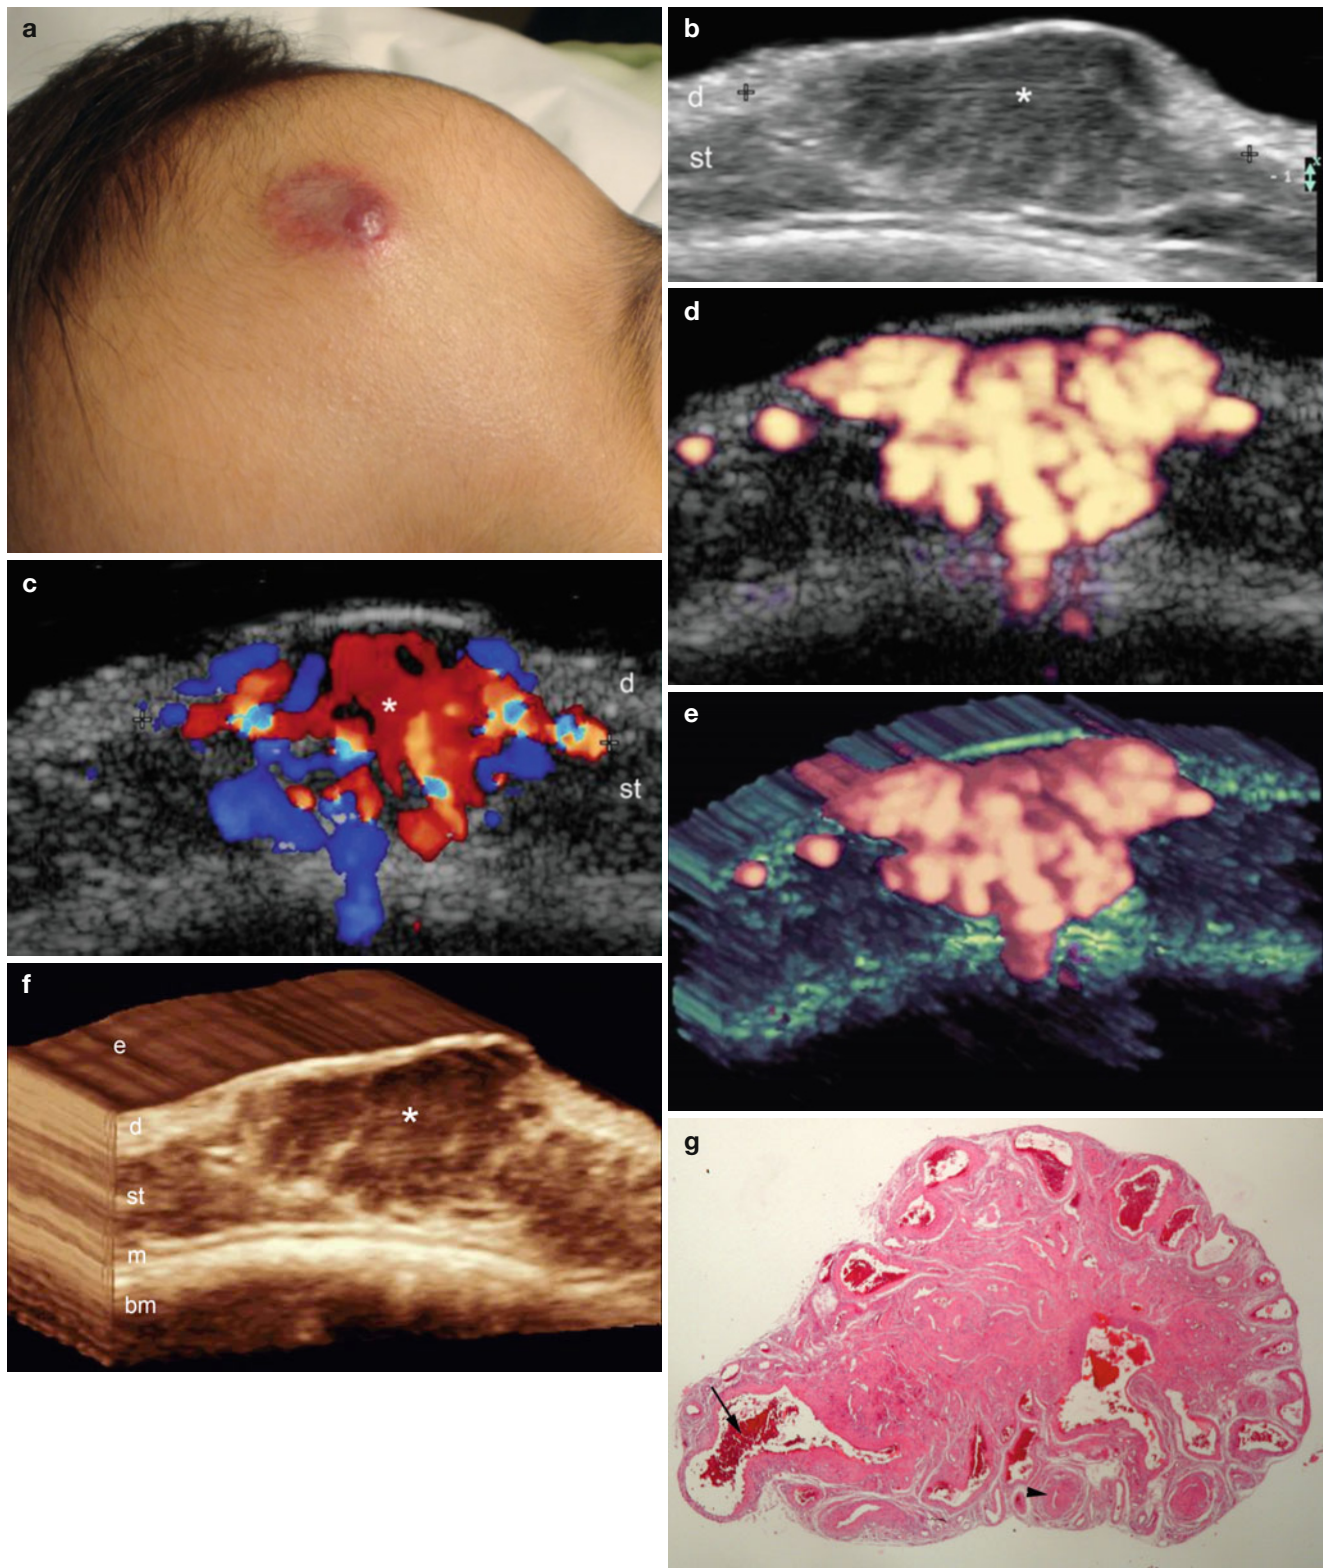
(a–g) Hemangioma. (a) Clinical image of the lesion in the frontal region. (b) Ultrasound image (gray scale, transverse view) shows hypoechoic and heterogenous mass (*) that presents ill- defined borders and involves dermis and subcutaneous tissue. The most hypoechoic area corresponds to the most proliferative part of the hemangioma. (c) Color Doppler ultrasound image (transverse view) shows prominent blood flow within the mass. (d) Power Doppler image (transverse view)
